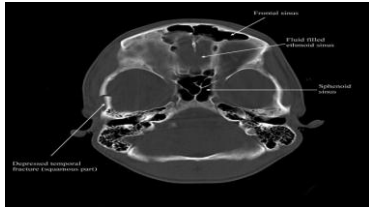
Demonstrate CT image of (Rt) temporal bone fracture (white arrow).
